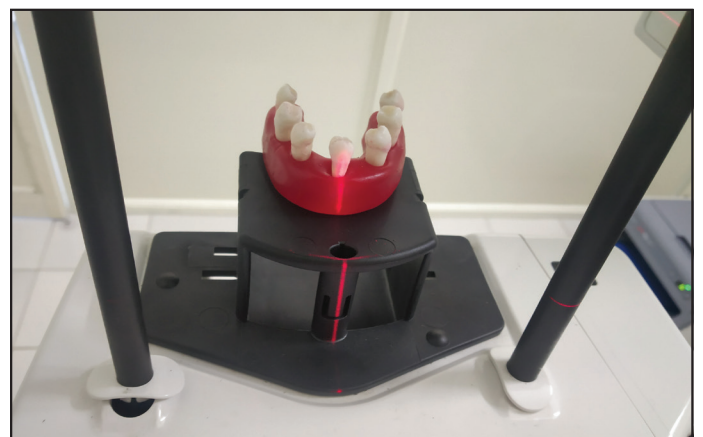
Pre-incineration CBCT of the samples
